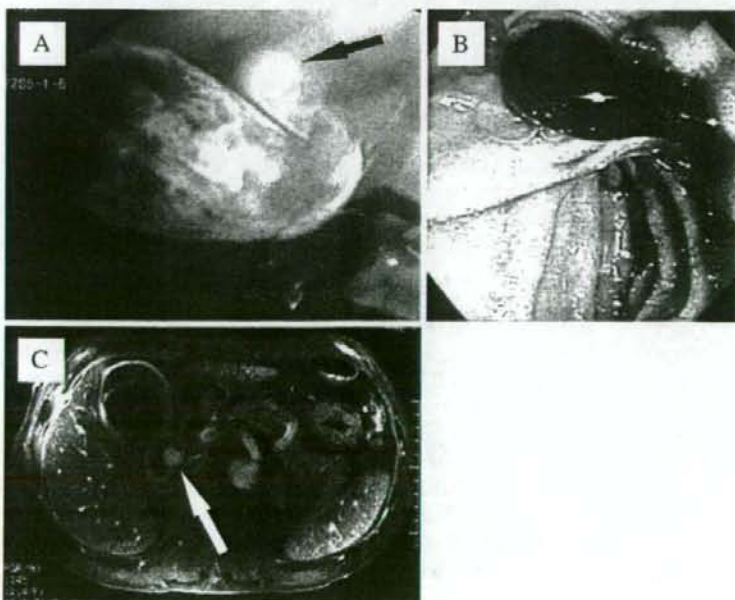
A Cholangiography via a percutaneous transhepatic gallbladder drainage tube showing irregular-shaped filling defects (intracholecystic hematoma) and gallstone impaction in the neck (arrow). B Side-view endoscopy demonstrating blood oozing from the papilla of Vater. C Dynamic magnetic resonance imaging showing an early-enhanced pooling of contrast material inside the neck of the gallbladder (arrow) in the same manner as in the abdominal aorta
